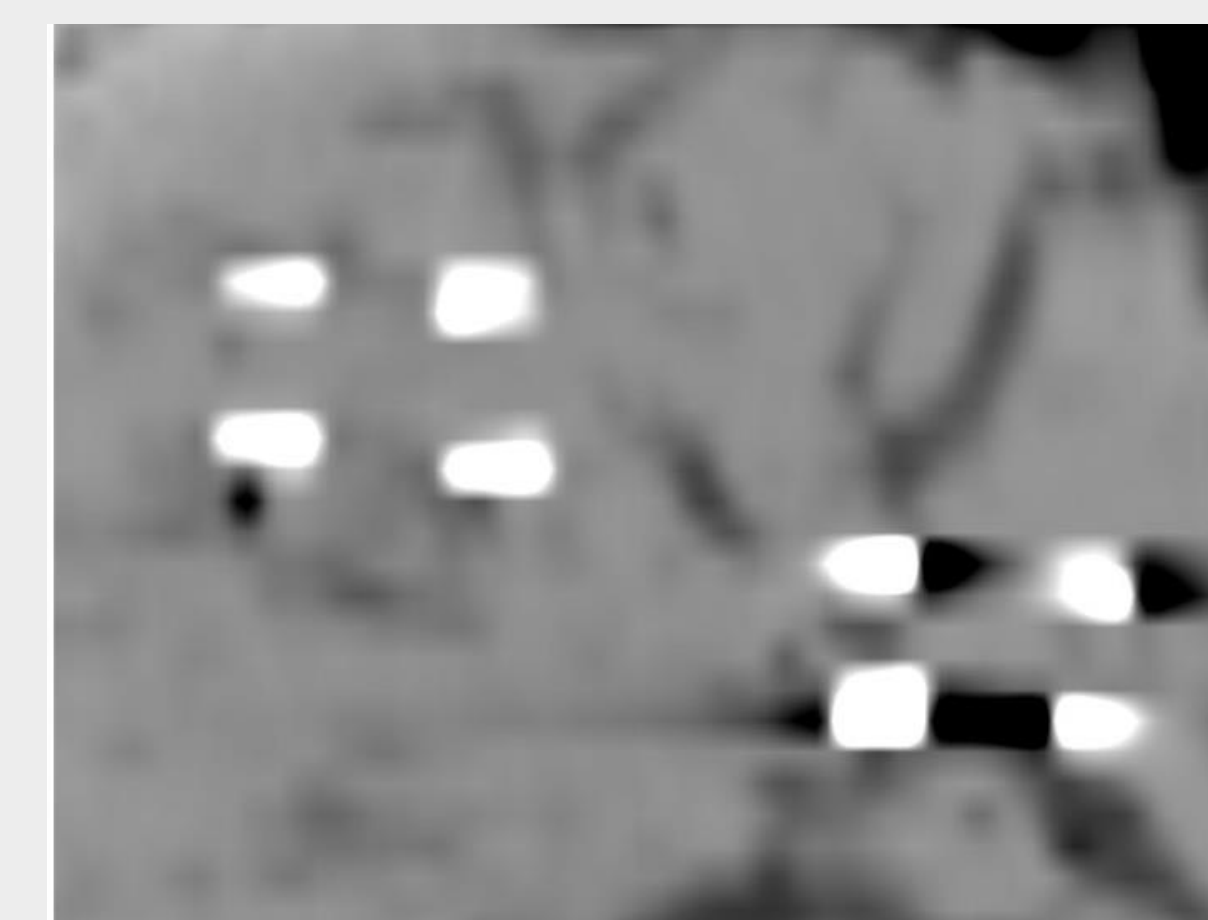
CT image from dataset 3 with gold-marker seeds on the right and no-marker seeds on the left
